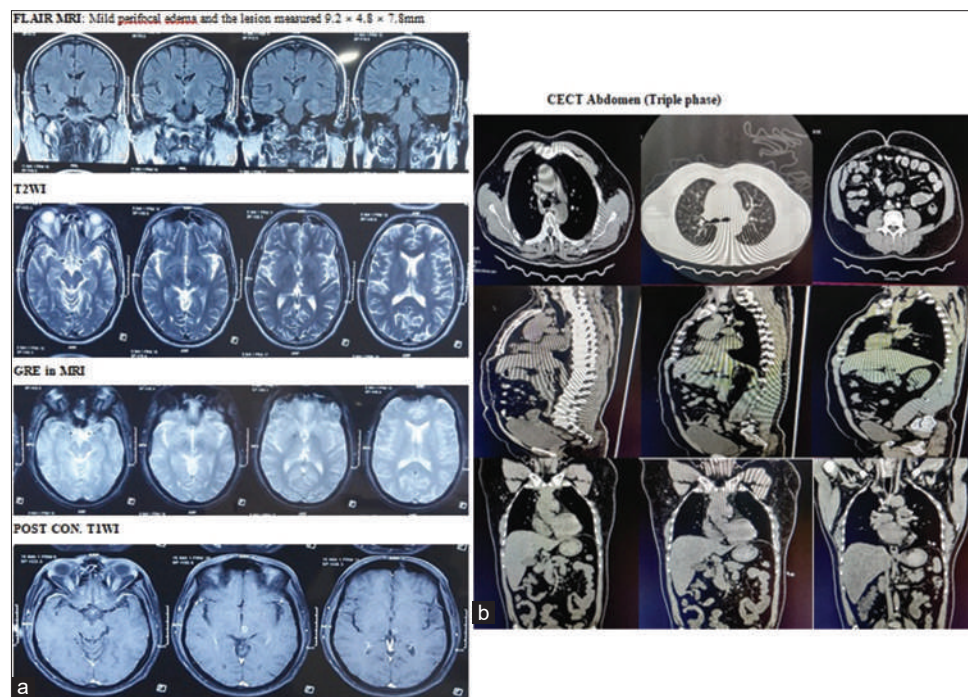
(a) MRI brain (plain+contrast) (b) CECT abdomen (triple phase)
